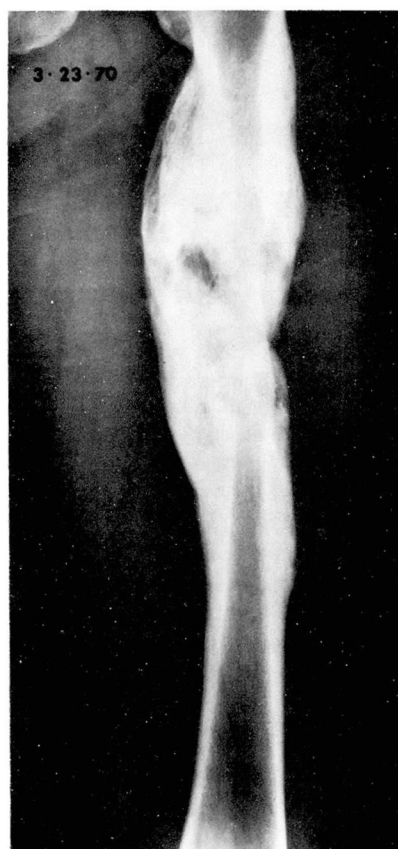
Roentgenogram of the femur taken in the healing phases of the chronic osteomyelitis.
